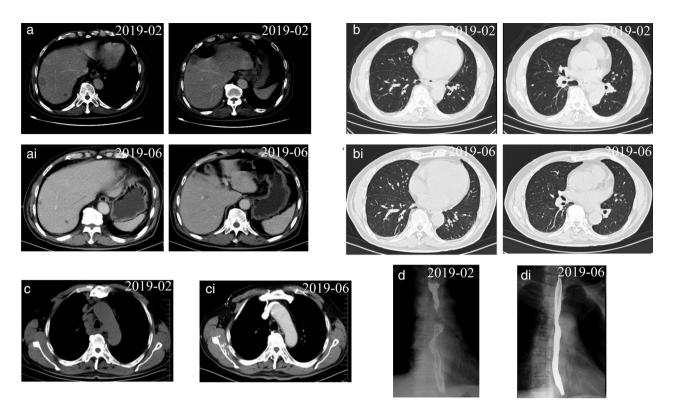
(a) Computed tomography (CT) scan showing liver metastases in February 2019; (ai) CT scan showing liver lesions which achieved a near complete response (nCR) after therapy; (b) CT scan showing lung metastases in February 2019; (bi) CT scan showing lung lesions which achieved a complete response (CR) after therapy; (c) CT scan showing lymph node metastases in February 2019; (ci) CT scan showing lymph node lesions which achieved aCR after therapy. (d) Barium meal imaging in February 2019. (di) Barium meal imaging after therapy.
